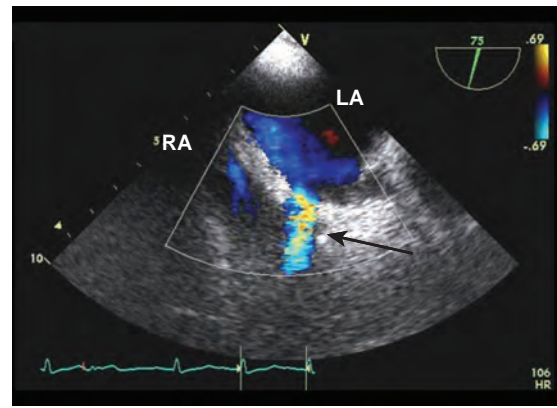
Transesophageal image from the midesophagus at 75 degrees focusing on the interatrial septum. Color-Doppler imaging readily reveals a moderately sized shunt from the left atrium (LA) to the right atrium (RA) through a patent foramen ovale.
